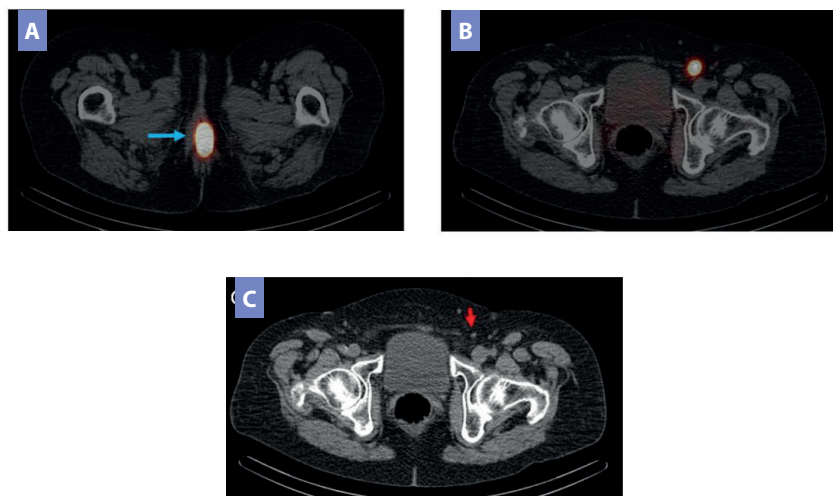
SPECT/CT image A) demonstrates intense activity at the vulvar injection site, blue arrow. Image B) shows discrete uptake in a left superficial inguinal SLN, which localises to a tiny left inguinal node on the CT component (red arrow, image C). *Courtesy of the Department of Nuclear Medicine, The Christie NHS Foundation Trust, Manchester.*
